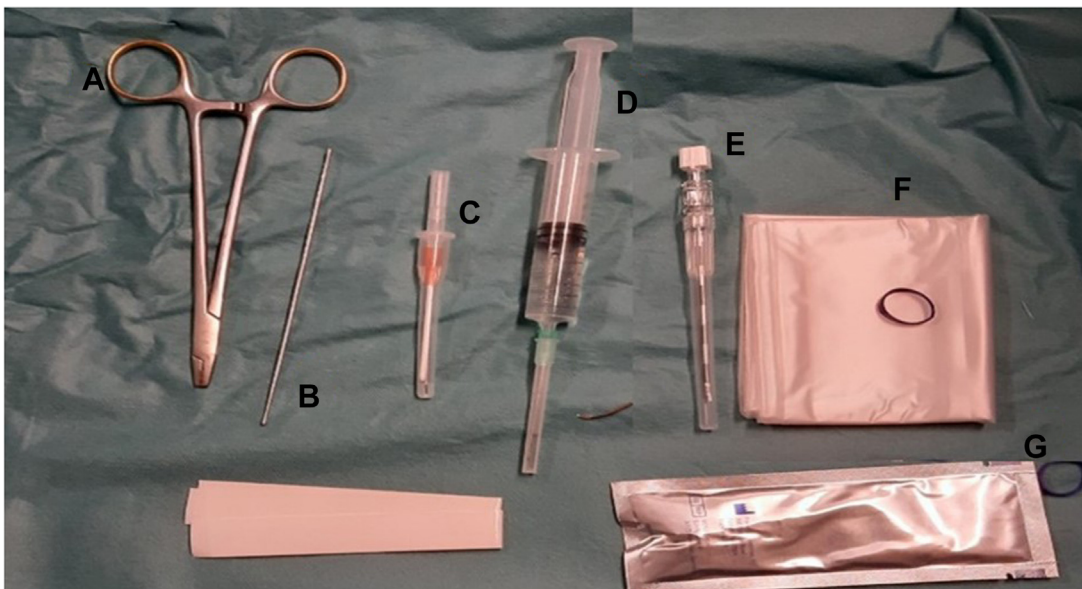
Instruments used for PCTR in our center: (A) needle holder, (B) buttoned stylus, (C) 14G catheter, (D) syringe with anesthetic product, (E) Tuohy catheter, (F) cover for sonography probe, and (G) sterile ultrasound gel.
